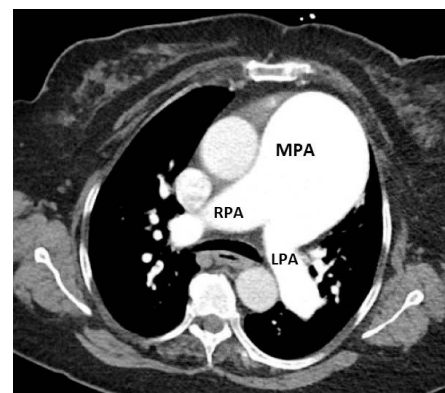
Chest computed tomography angiography, axial view, demonstrating dilated main (MPA), right (RPA), and left pulmonary arteries (LPA).
